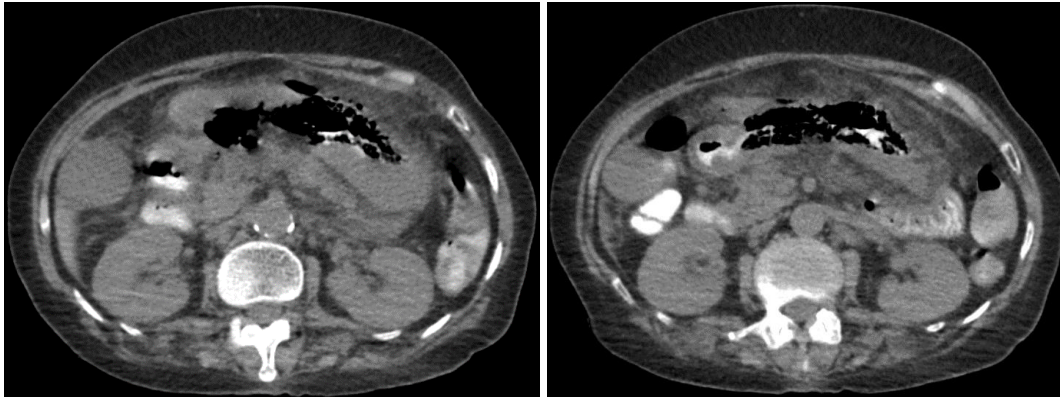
A computed tomography (CT) showing a significant thickening of stomach wall with specks of air along the stomach, suggestive of a possible sealed perforation or emphysematous gastritis.
